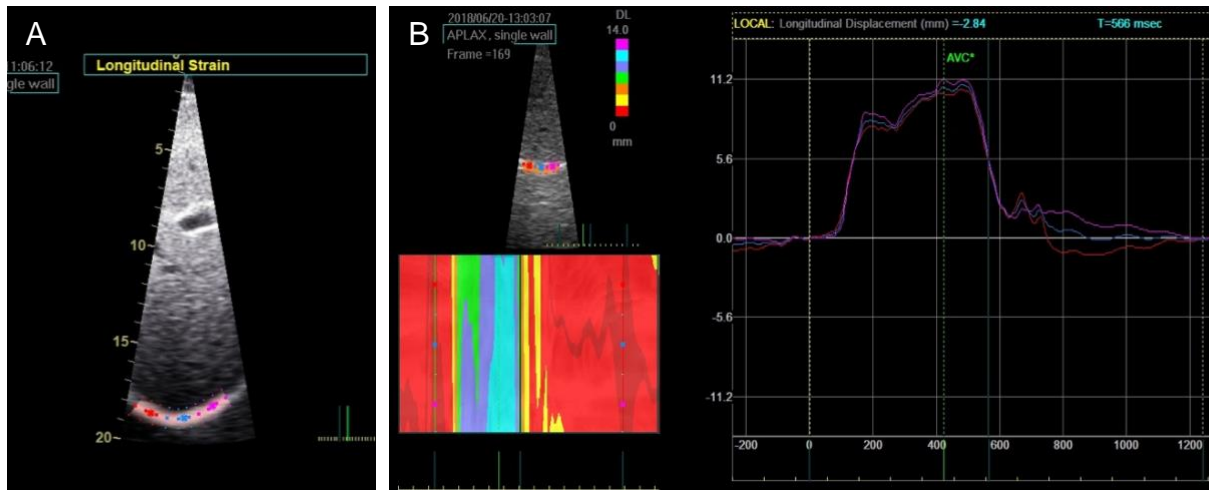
A) Speckle-tracking analysis of diaphragm excursion in response to a sniff. The region of interest (ROI) was drawn on the B-mode ultrasound and automatically divided into three sub-regions, distinguished by colours red, blue and pink. B) Diaphragm excursion expressed as a time-capture, with the ordinate representing excursion (mm) and the abscissa as time (ms).
